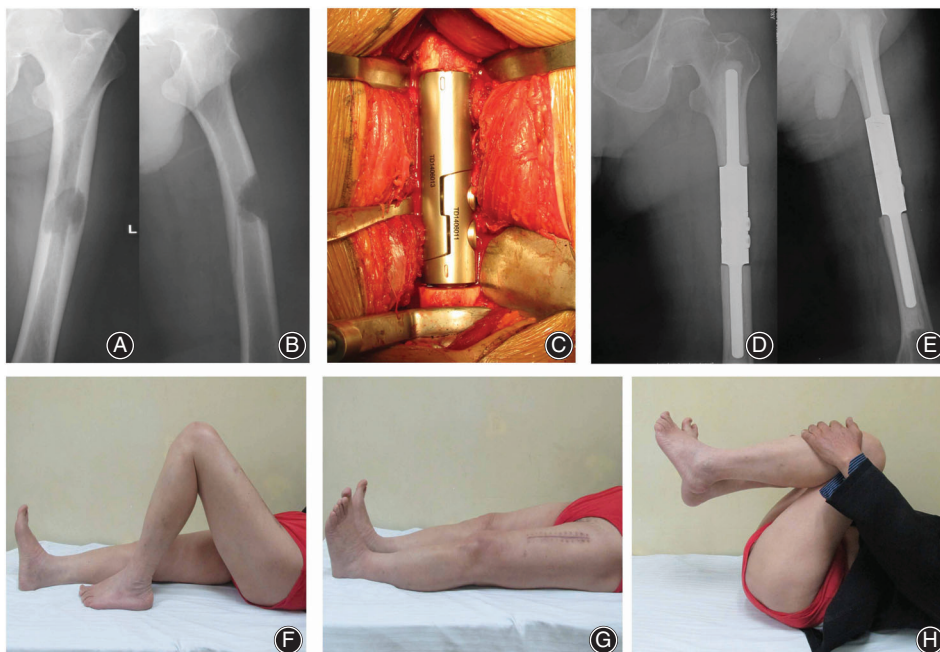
Femur metastasis (modified score system, MSS = 12) treated with intercalary segmental endoprosthesis. A 78-year old male patient had metastases in his left femur, (A, B) Preoperative radiographs demonstrating an osteolytic lesion located in the diaphysis. (C) Intraoperative fixation of a modular segmental endoprosthesis after wide resection of the tumor. (D, E) Postoperative radiographs of the implant. (F-H) The patient's limb function was well preserved at 12 months postoperatively.
